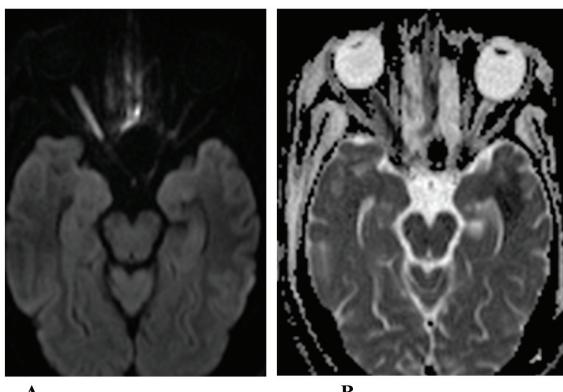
Optic nerve ischemia in a post Covid patient: A&B: Axial DWI and ADC map shows diffusion restriction in right optic nerve indicating infarction.
